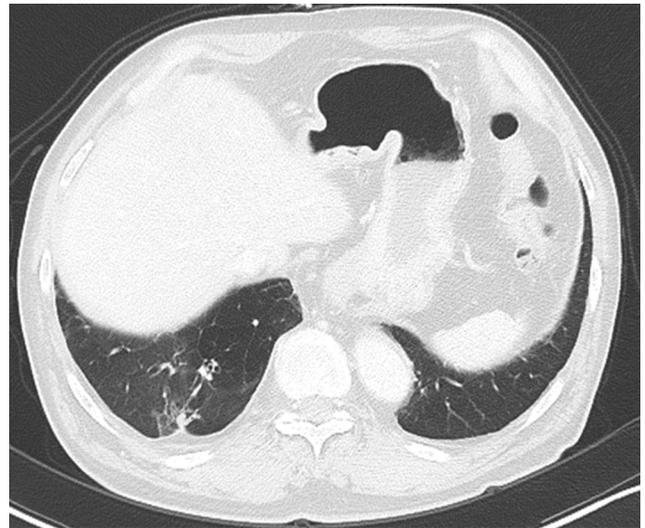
A CT scan after 6 months of erlotinib treatment showed that the nodule in the right lower lobe had shrunk and the pleural effusion had decreased.
